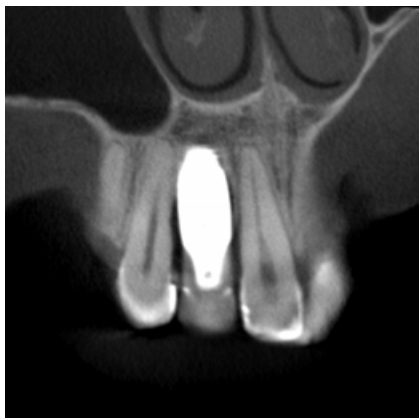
Coronal CBCT slice
